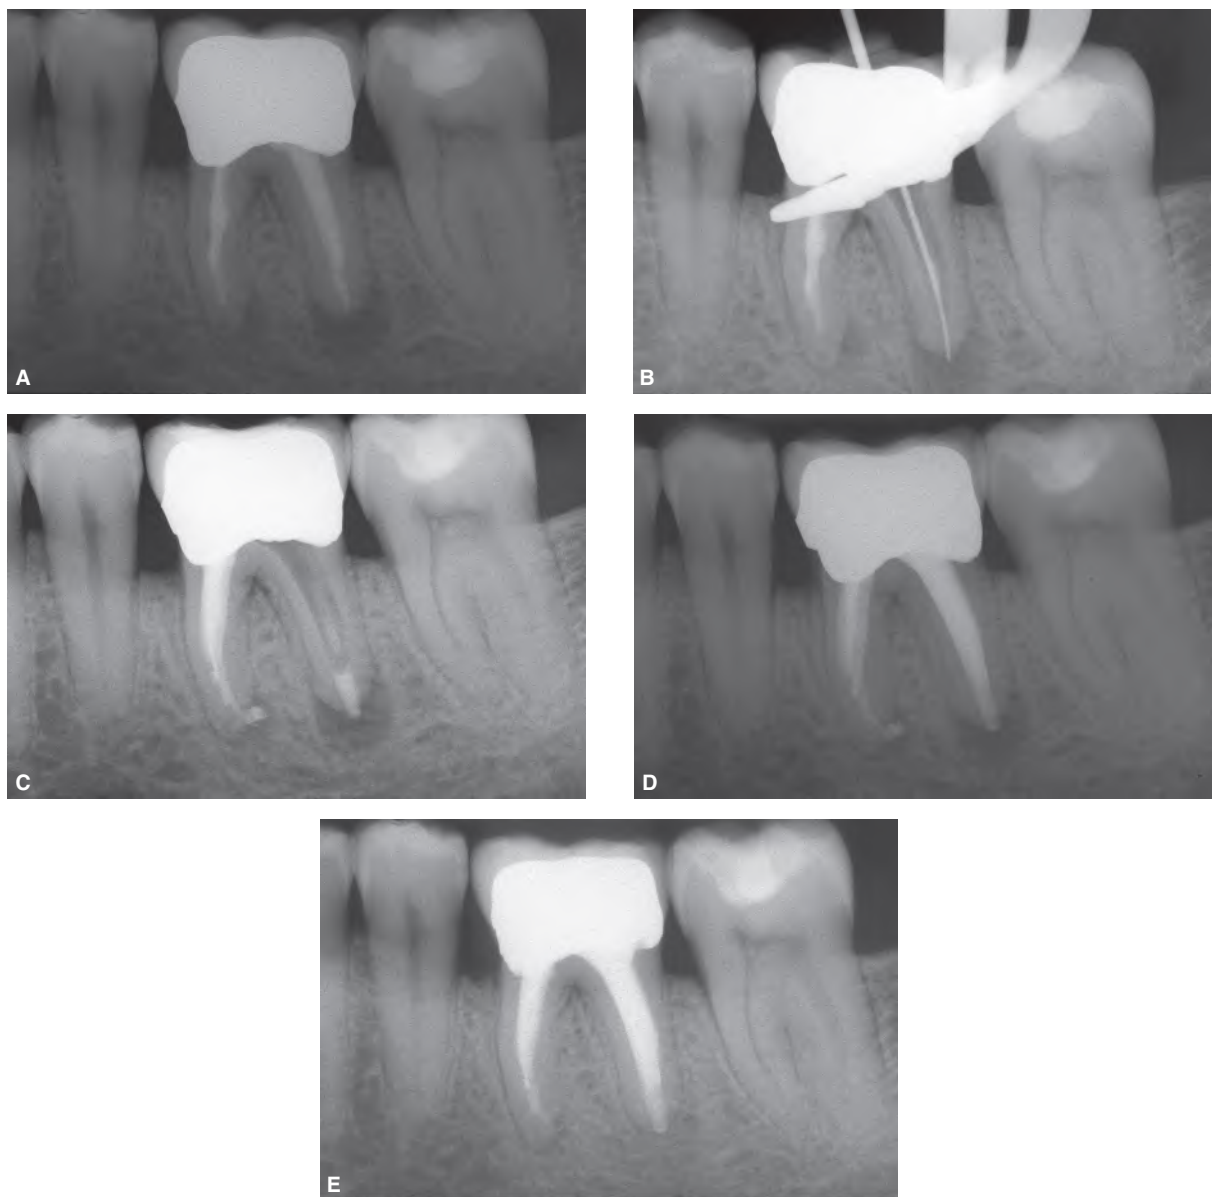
Endodontic retreatment in a mandibular left first molar using MTA. A. Preoperative radiograph. B. Working length of the distal canal. The size of the apical foramen is larger than a #50 instrument. C. Three millimeters of gray MTA were placed at the apical end. D. Postoperative radiograph showing the apical 3 mm of the root canal obturated with MTA. E. One-year recall radiograph showing healing of the lesion.
